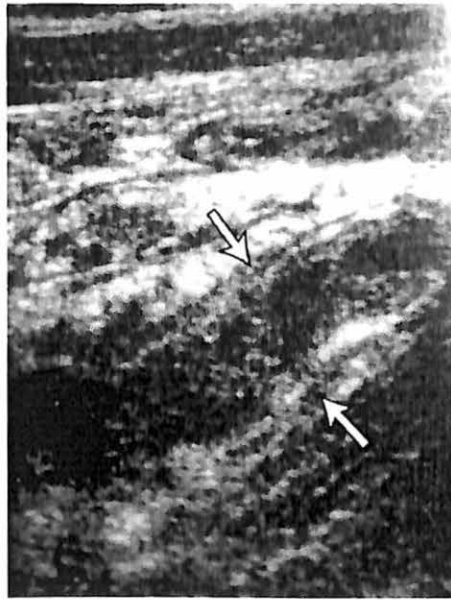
(c)(ii) shows the ultrasonographic feature of acute appendicitis with distended lumen and oedematous wall.
